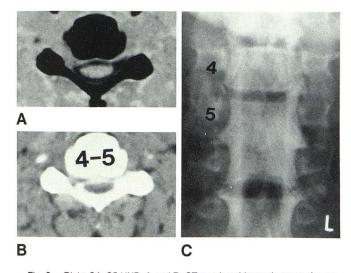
Right C4–C5 HNP. $\bf A$ and $\bf B$, CT metrizamide myelograms demonstrate right C4–C5 HNP. $\bf C$, Only minimal asymmetry of right C4–C5 nerve root sleeve is seen on myelography.
